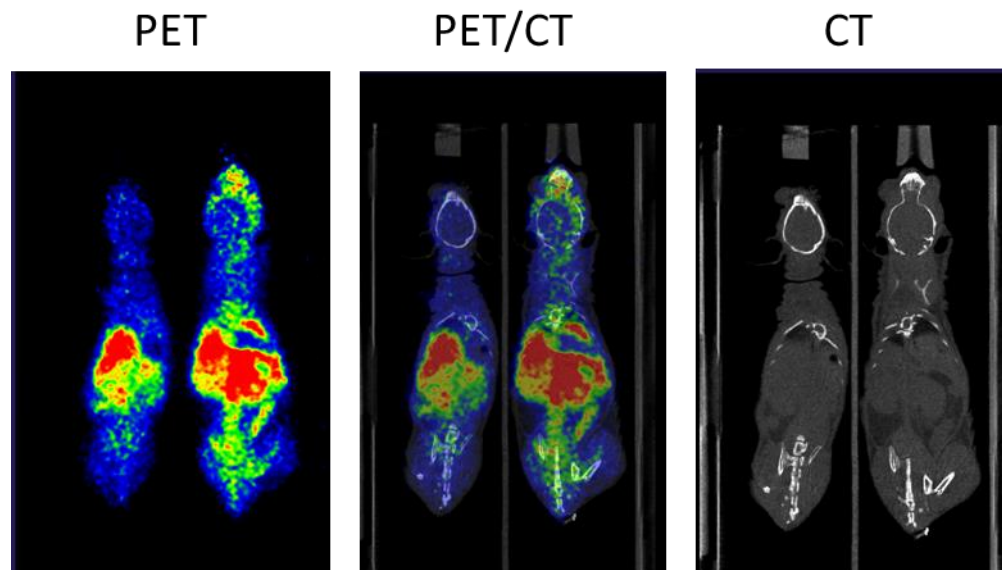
Screenshots of the visualization of PET/CT image with both functional and anatomical information after registration.
